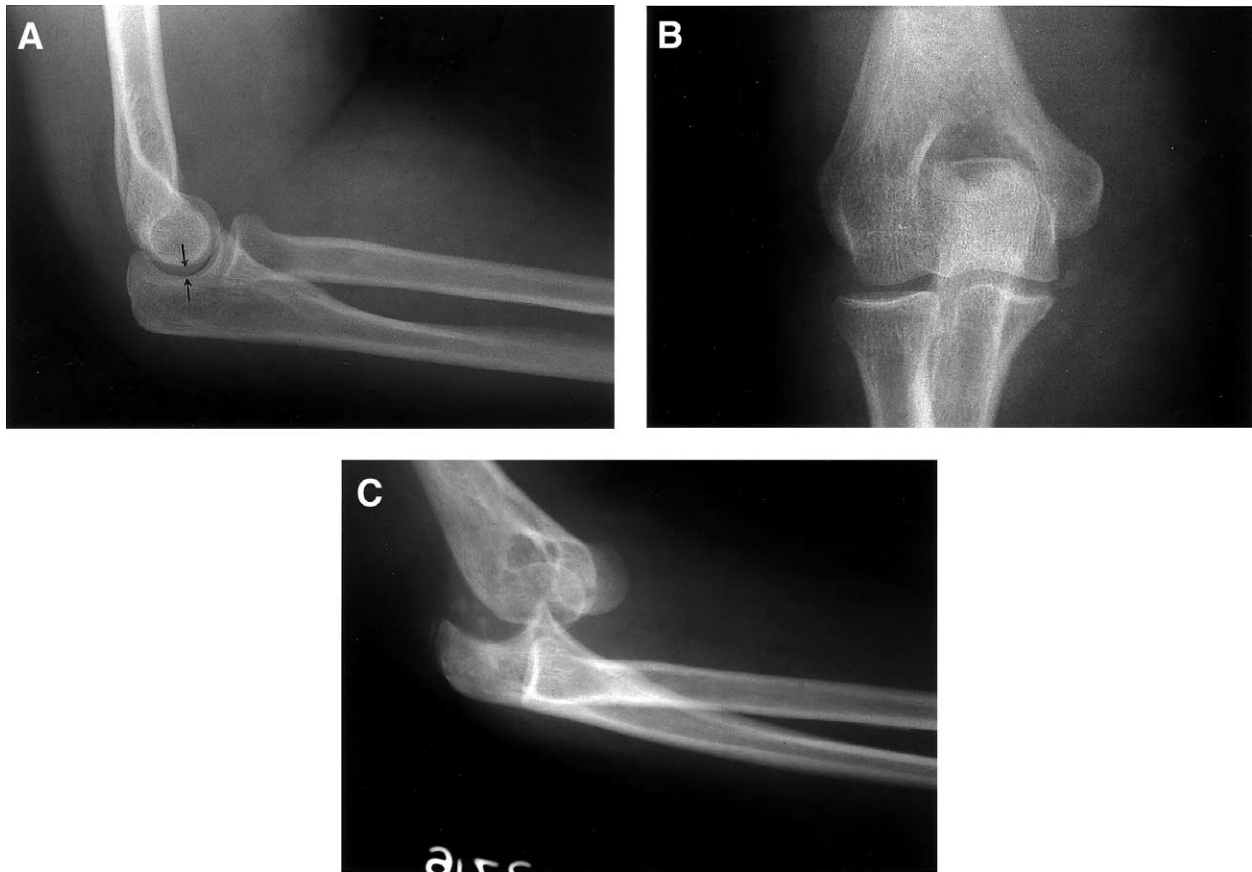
A 68-year-old woman sustained a Smith-type fracture of the distal radius. Concomitant radiographs of the elbow (A and B) were interpreted as being negative for osseous injury. A drop sign was not noted on the lateral film at that time. Occult dislocation of the elbow occurred while the patient's arm was immobilized in a long arm cast for the wrist fracture, was discovered 5 weeks after injury (C), and required open treatment. Complete tears of the medial and lateral ligament complexes were found at operation.
